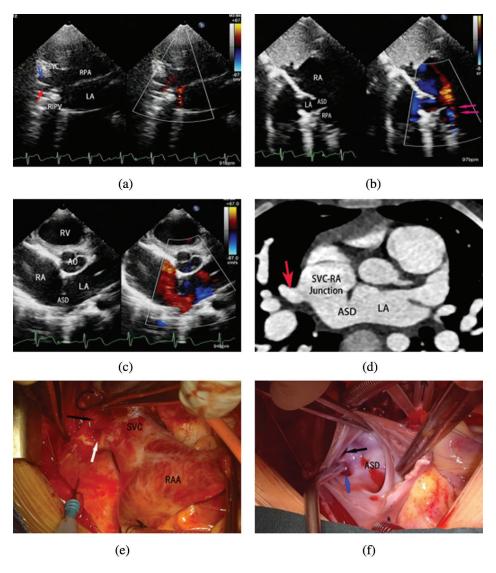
Right-sided PAPVC and associated superior SVD. (a) Supra-sternal echocardiographic view. RSPV (blue arrow) and RMPV (red arrow) connecting to SVC-RA junction. (b) Subcostal sagittal echocardiographic view shows a superior SVD/ASD. Arrow indicates SVC. (c) Parasternal short axis echocardiographic view. There was no posterior interatrial septal rim between ASD and posterior atrial wall. (d) Multiplanar reconstruction of multidetector CT showed RSPV connecting to SVC-RA junction. Absence of posterior rim of ASD was also observed. (e, f) Opened-up RA showed RSPV (black arrow) and RMPV (blue arrow) returning abnormally. An ASD in superior and posterior part of atrial septum with no residual posterior atrial septal tissue. (PAPVC, partial anomalous pulmonary venous connection; SVD, RSPV, right-sided pulmonary vein; RMPV, right middle pulmonary vein; SVD, sinus venosus defect; SVC, superior venous cava; RA, right atrium; ASD, atrial septal defect)
